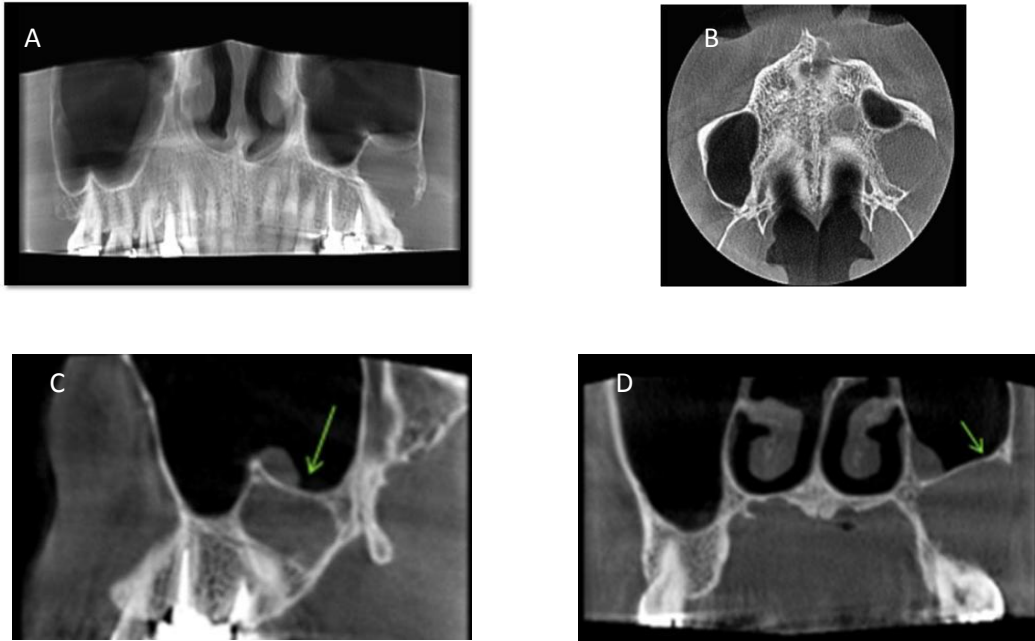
A-D: Reconstructed panoramic (A) and axial view (B) of CBCT showing a unilocular radiolucent lesion of the posterior maxilla. Thinned, bowed, and slightly expanded bony cortex is observed in the area. Note to the superior displacement of the maxillary sinus floor in coronal and sagittal views(C&D).
